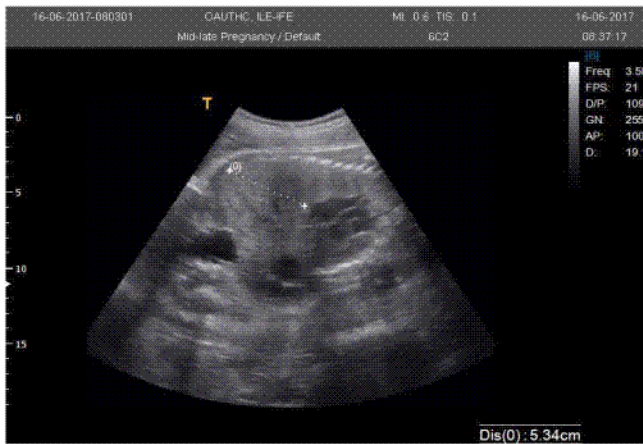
Longitudinal B-mode ultrasound scan of foetal abdomen showing measurement of FLL (cephalo-caudal length) indicated by the calipers, from the dome of right hemi-diaphragm close to right cardiac border to the caudal end of right lobe of the liver in the coronal plane.
